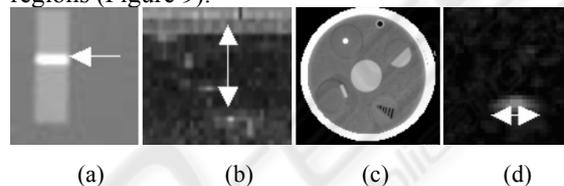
Typical examples of distance measurements in CT (a and c) and US (b and d) images.
